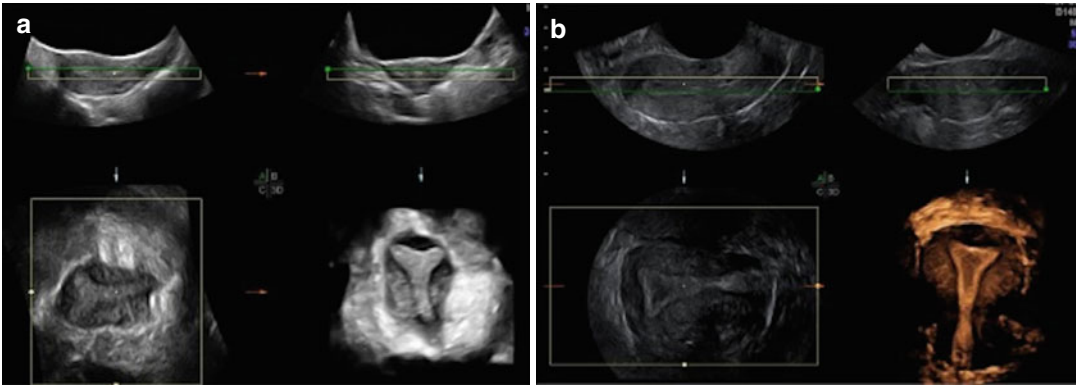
3D sectional planes and rendered image of a normal uterus ESHRE/ESGE U0 C0. (a) abdominal ultrasound. (b) vaginal ultrasound
